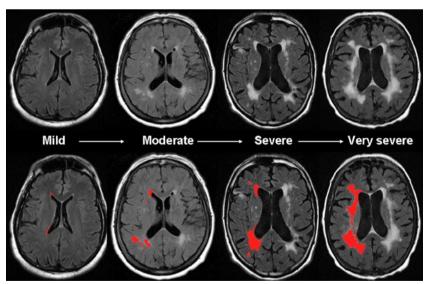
Severity of MRI-detected white matter hyperintensity. Total burden of white matter disease varies significantly among asymptomatic adults and patients with known cerebrovascular disease. In age-matched individuals, white matter hyperintensity (WMH) volume may vary from mild to very severe (upper panel). Using validated semi-automated volumetric protocol, WMH volume can be guantified (lower panel, in red, WMH maps are derived from contiguous supratentorial axial T2-FLAIR MRI slices using previously published method [10]) with a high degree of accuracy and precision.
